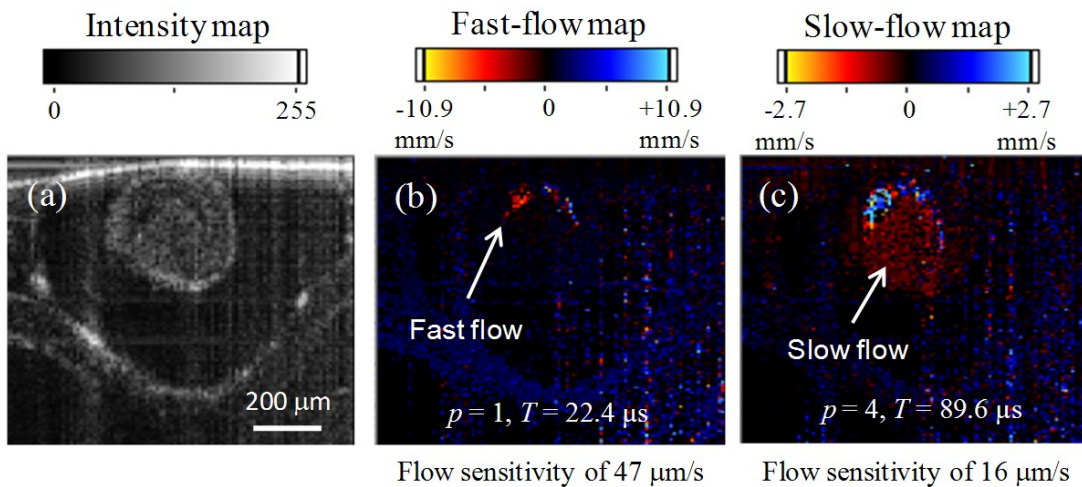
(a) Conventional intensity image, (b) fast-flow Doppler image, and (c) slow-flow Doppler image acquired at the same location of the tadpole heart region.
